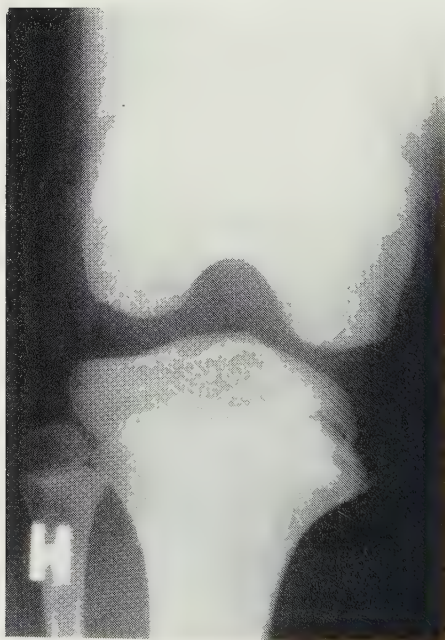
Radiographic examinations in Mb. Blount of juvenile type.
